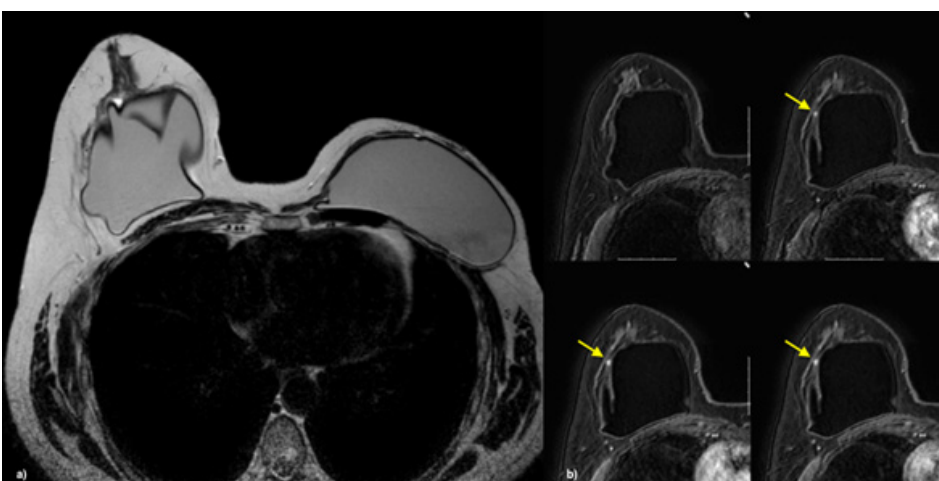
Follow-up MRI in a left mastectomized woman with reconstruction with bilateral implants. Assessment of T2-weighted sequences (a) revealed no signs of prosthesis-related complications. However, in the post-contrast (b) dynamic study, the presence of a focus of enhancement was verified, which after a second-look ultrasound study and echoguided micro biopsy, an invasive ductal carcinoma was found.
